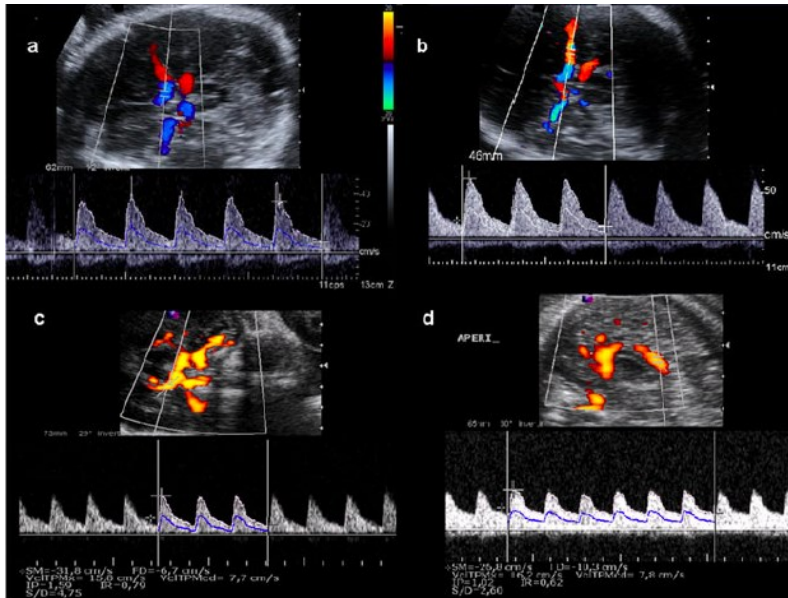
Pulsed Doppler evaluation of the major fetal cerebral arteries: (a) anterior cerebral artery segment 1, (b) middle cerebral artery, (c) posterior cerebral artery segment 2, and (d) pericallosal artery
